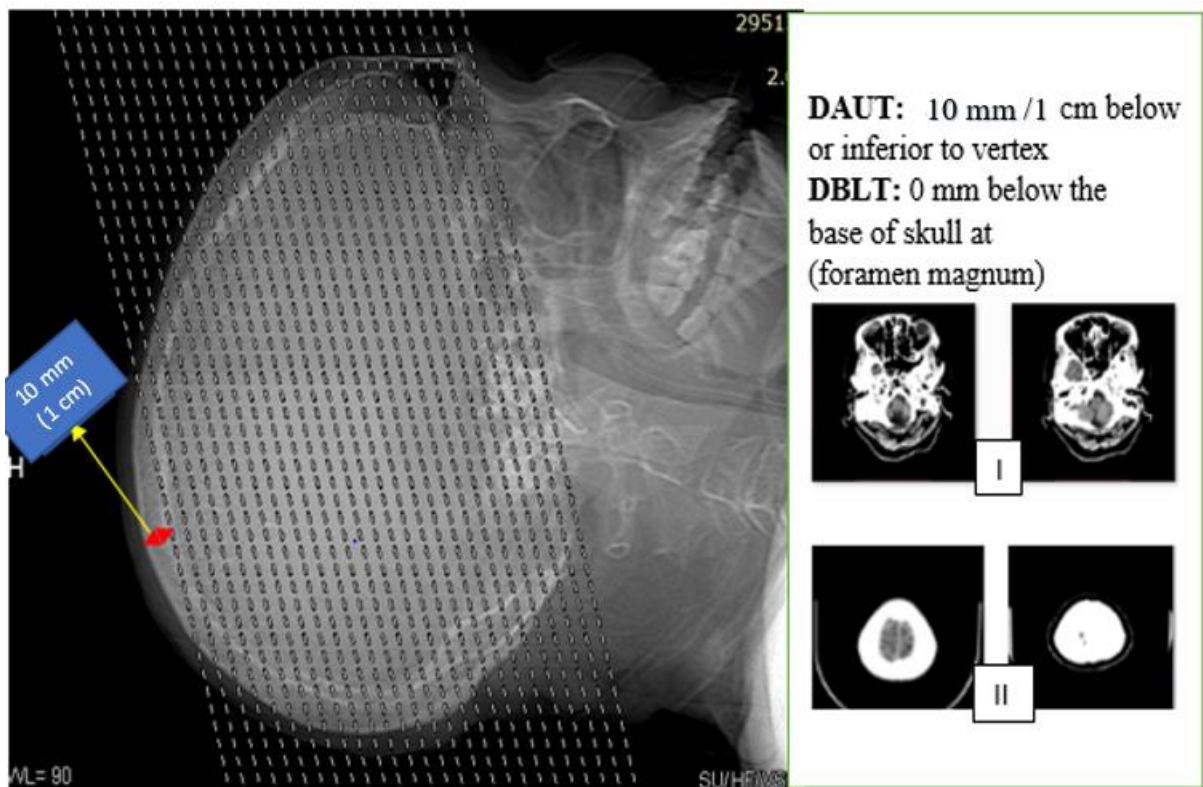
A typical scan coverage (grid areas) for a “Reduced range” CT for CVA. Plate I shows the last two slices from the skull base (caudally) and Plate II shows the last two slices cranially. The red arrow shows a 1 cm allowable distance from the vertex of the skull that can be used to optimise radiation in CVA examinations without compromising on image quality.
